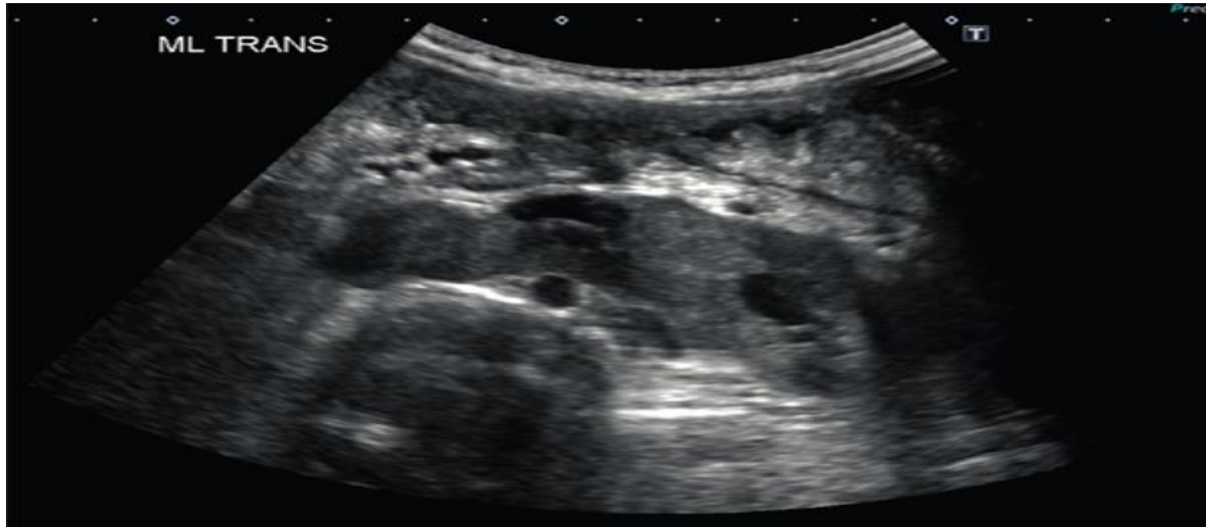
Newborn with cloacal anomaly. Abdominal sonogram shows horseshoe kidney with mild dilation of the right and left collecting system. Note right side with anterior renal pelvis.³
